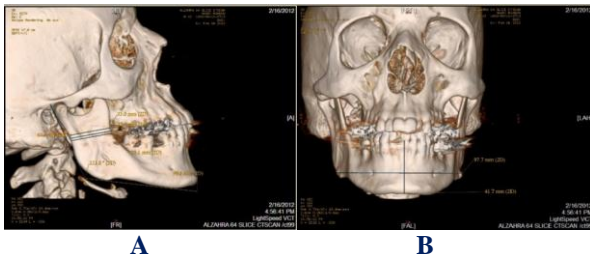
Measurements on 3D CT images for man with 42 years old in Alzahra hospital (A,B)
